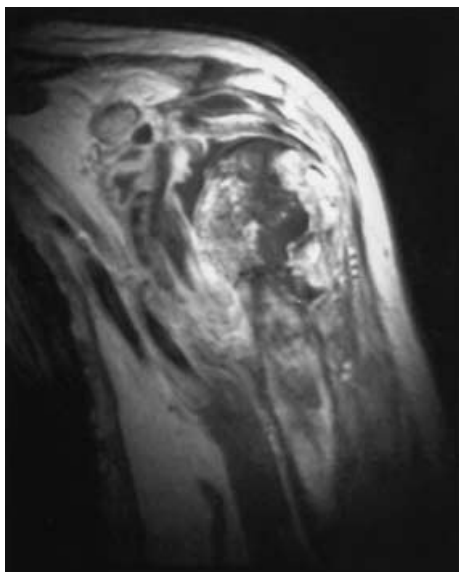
Magnetic resonance imaging (MRI) of a 59-year-old patient with a known history of NHL. The coronal, T1-weighted, contrast-enhanced SE image of the proximal humerus shows a disseminated tumor infiltration of the bone with a pathologic fracture. The patient underwent resection and implantation of a tumor prosthesis. At 59 months after chemotherapy and radiotherapy, there is no evidence of disease
